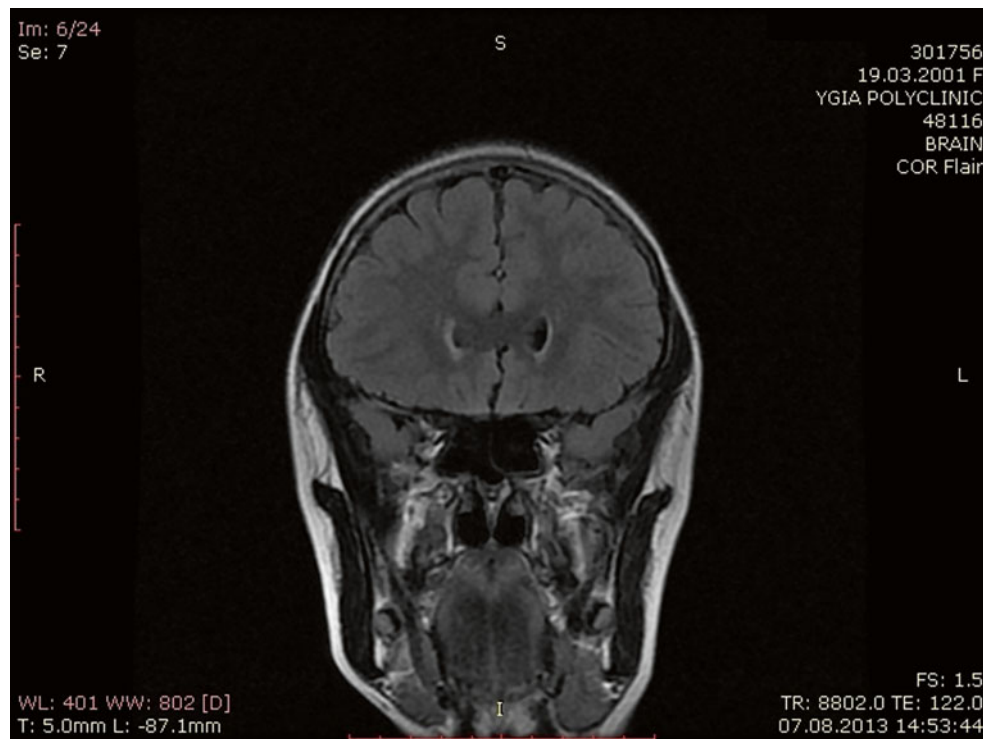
Coronal MRI in FLAIR mode, the anterior part of the brain in a 12-year-old girl, with remote consequences of perinatal HI-BI, current encephalopathy, and the presence of periventricular gliosis around the anterior horns of the lateral ventricles
